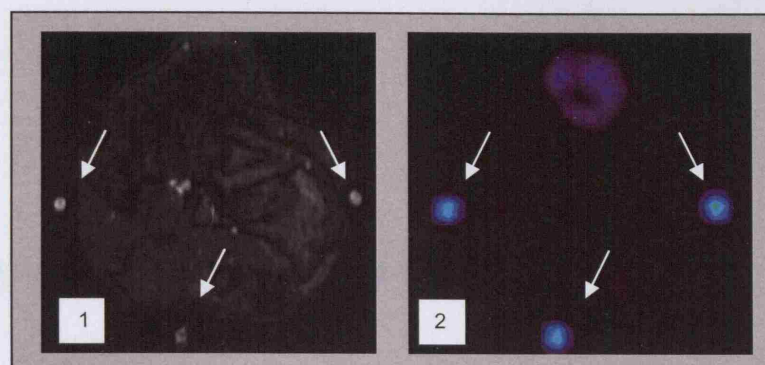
A T1 MRI image with fiducial markers arrowed at axial mid-point of tumour (1). Corresponding ^{64}Cu -ATSM microPET image (2)
